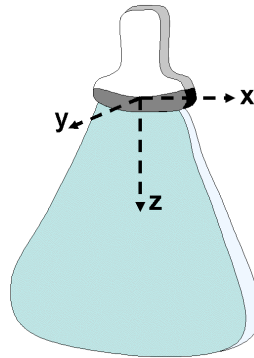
Ultrasound imaging geometry for 2D acquisition. The tissue imaged lies in the x-z plane.
